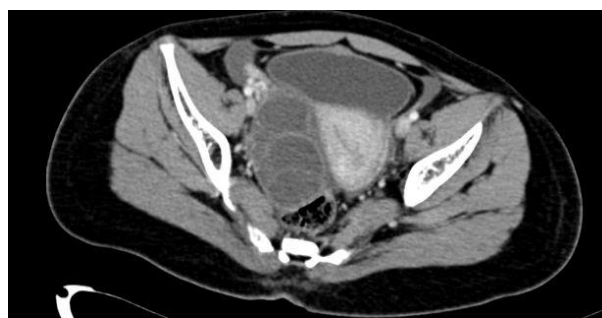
CT picture shows bilateral theca lutein cysts
